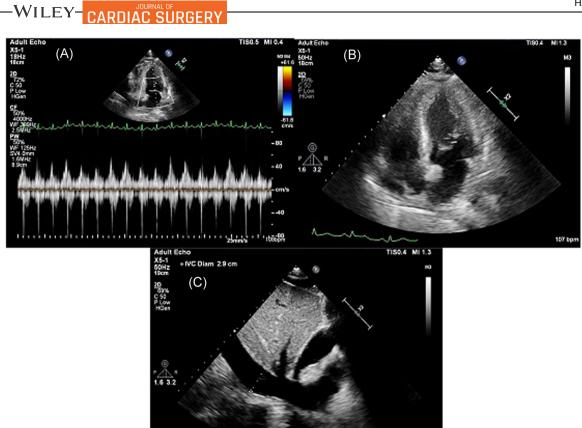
A, Top left, continuous wave Doppler through the mitral valve in the two chamber apical view: This image shows significant (>30%) respiratory variation in mitral inflow velocity. B, Top right, apical four chamber view: There is a moderate size effusion adjacent to the right atrium with partial right atrial collapse. C, Bottom, subcostal view: The inferior vena cava is plethoric measuring 2.9 cm
